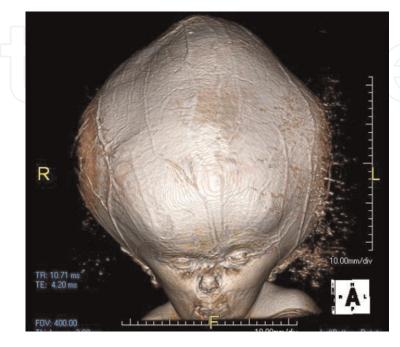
Three-dimensional reconstruction of the CT image of child's head with hydrocephalus.
